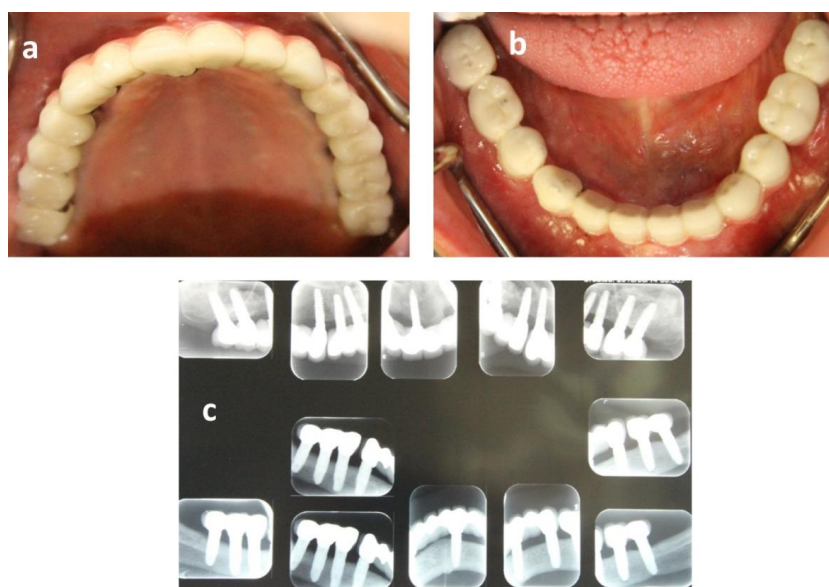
Post treatment documents: a) maxillary view b) mandibular view c) radiographic view
